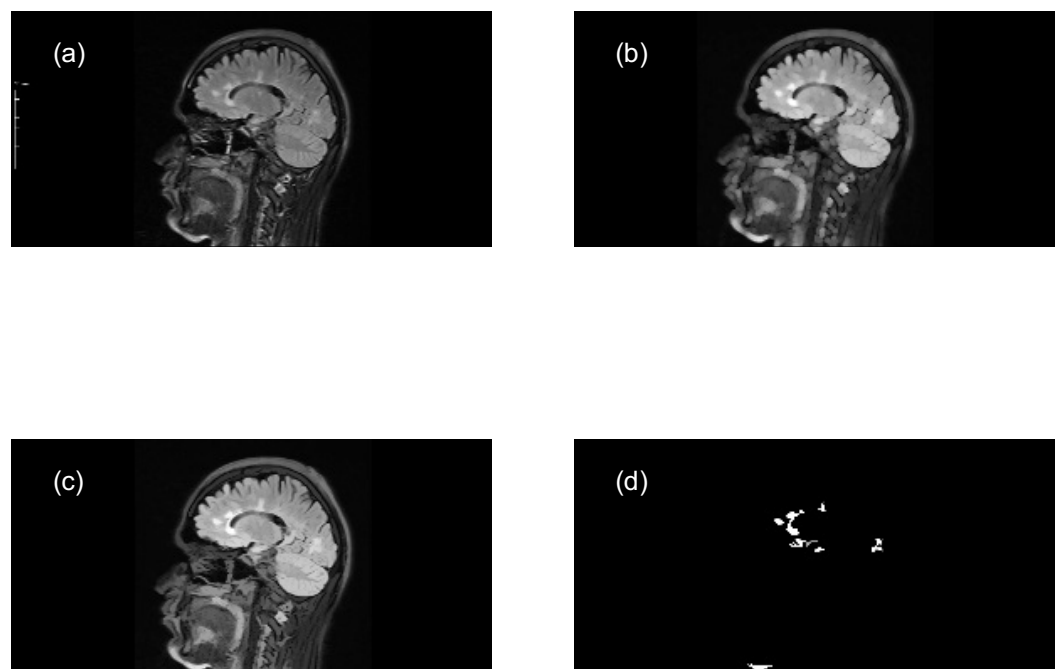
Implementation of opening morphological transformations: (a) Mask image (MS sagittal). (b) Morphological opening. (c) Opening by reconstruction. (d) Intensity adjustment. One of the targets of the first stage was to highlight the lesion areas in MS samples (sagittal MRI scans) using a disk-shaped SE of radius $r = 5$.
